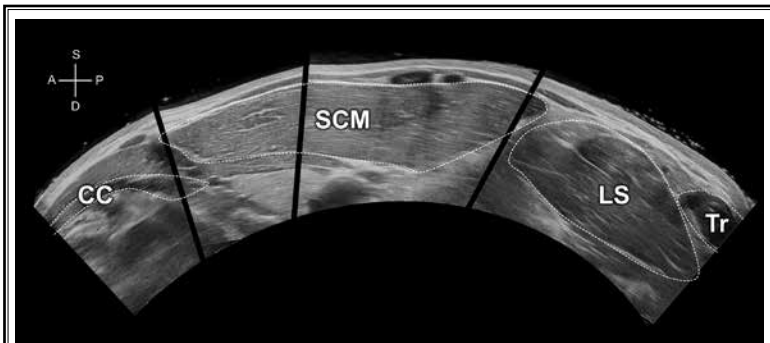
Ultrasonography (US) scan and the corresponding US panoramic image were used to visualize the muscle arrangement at the C6 level for guiding the injection into the levator scapulae muscle (LS). The probe was positioned transversely and scanned from the anteroposterior direction, revealing the trapezius (Tr), LS, sternocleidomastoid muscles (SCM), and cricoid cartilage (CC). The muscles appeared hypoechoic, while the fascial structure, including the prevertebral fascia, appeared hyperechoic. A, anterior; P, posterior; S, superficial; D, deep
